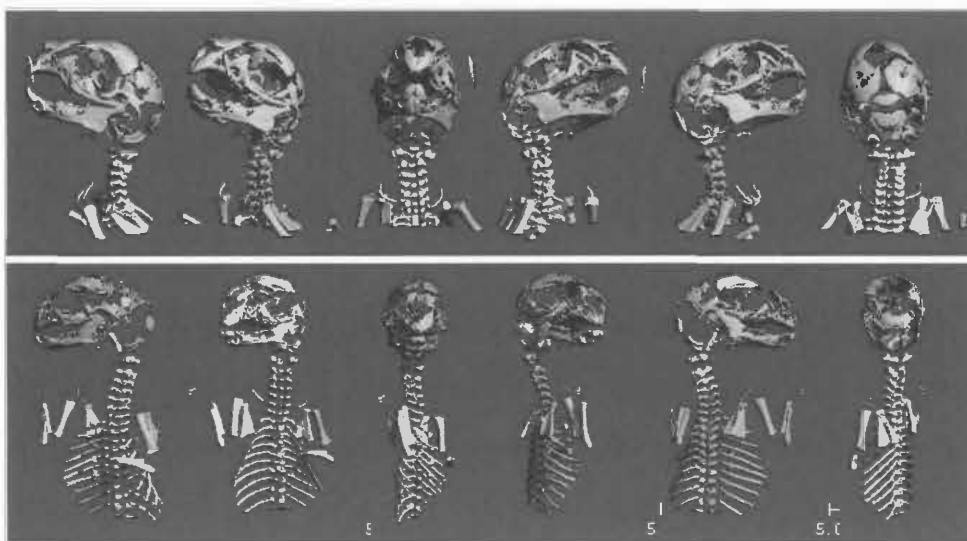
CT head and upper body image
